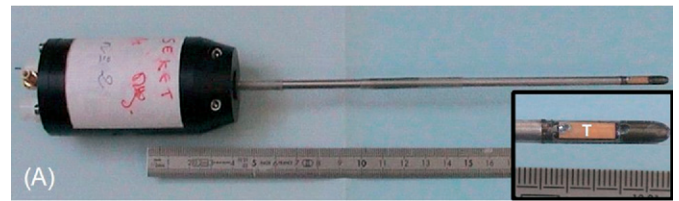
(A) Interstitial ultrasound probe used in this project. The transducer (T) is aimed laterally. (B) Operative device with ultrasound probe positioned under ultrasound guidance and kept in place in the liver by the pneumatic support. (Color version of figure is available online.)
